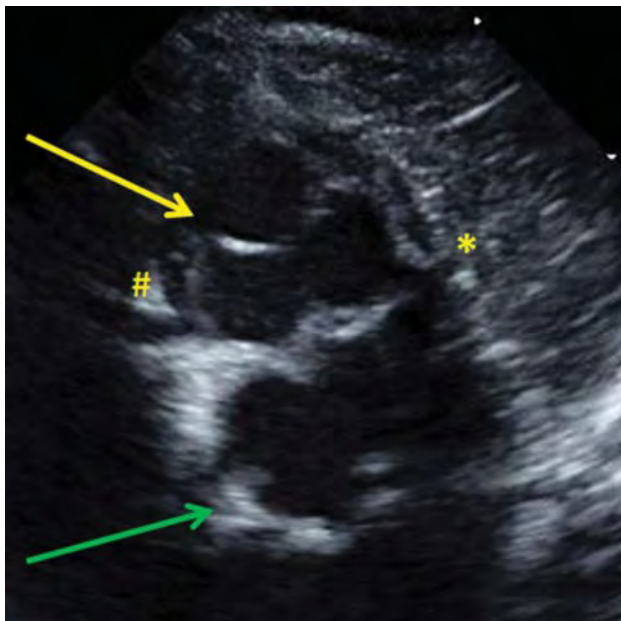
Echocardiogram: parasternal short-axis image displaying the anterior and slightly rightward aortic valve (yellow arrow) and posterior pulmonary valve (green arrow). The origins of the right (#) and left (*) coronary arteries can be seen arising from the facing sinuses of the aorta.
